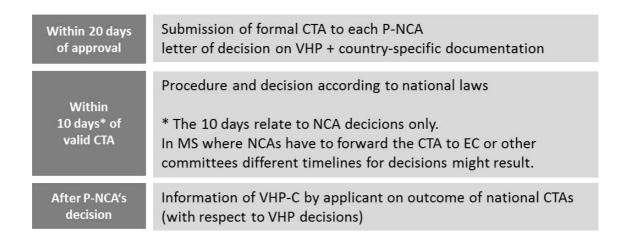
Phase 3 - VHP CTA National Step (modified according to [5])
